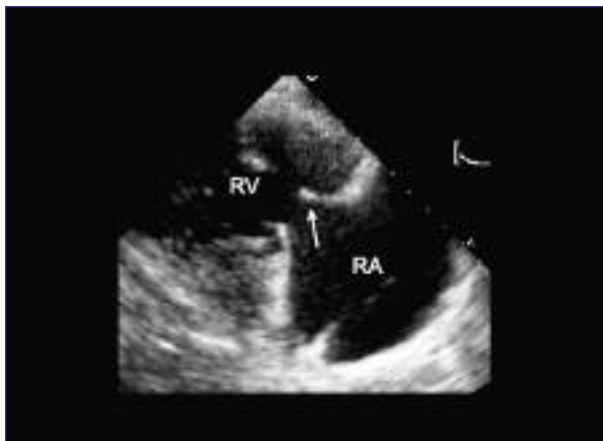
A RV inflow view on transthoracic ECHO demonstrating fixed, immobile leaflets of the TV (arrow), consistent with carcinoid heart disease.
